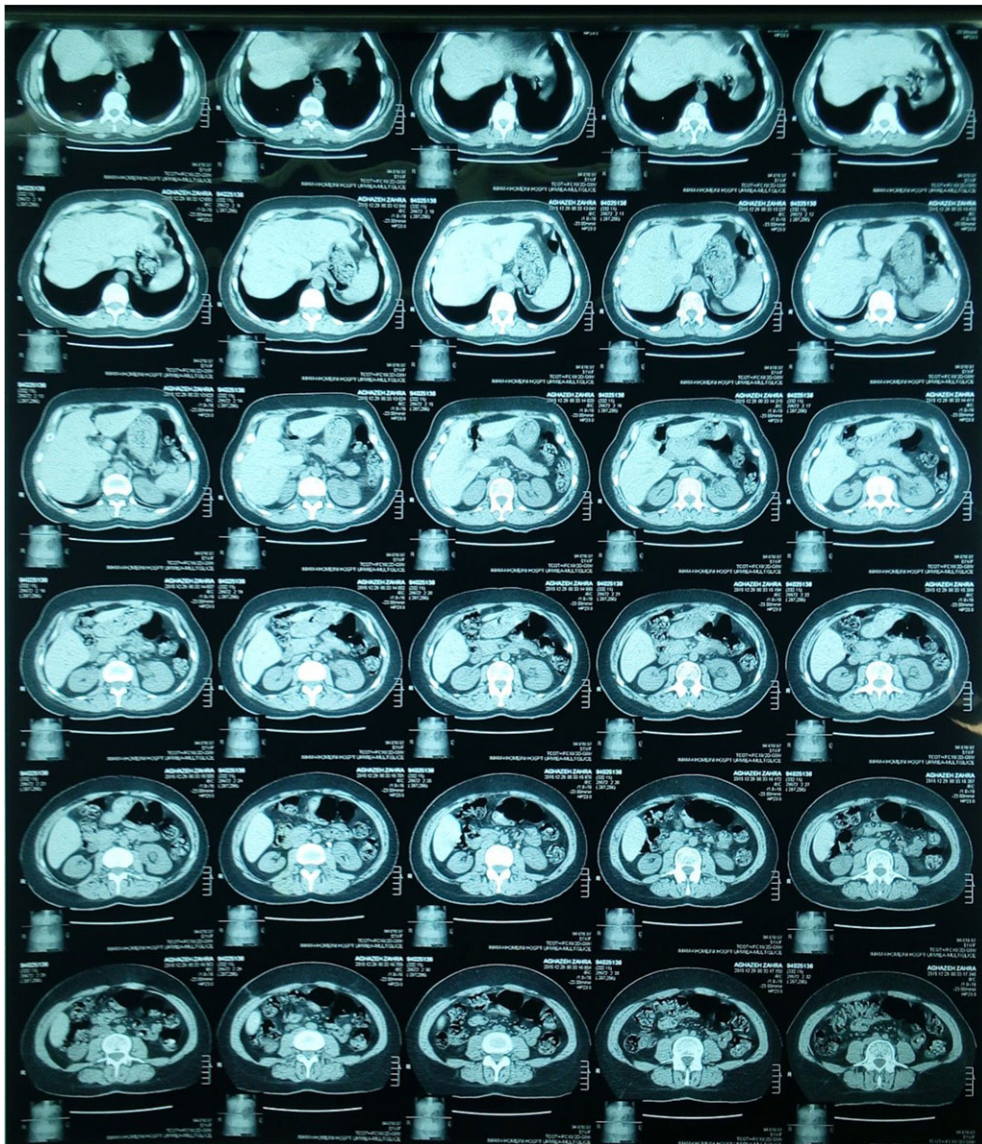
Abdominopelvic spiral CT scan of the patient before surgery.
